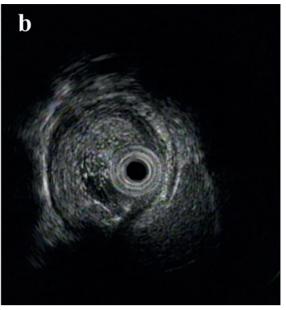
(a) Esophagogastroduodenoscopy revealed a yellowish, elastic, hard submucosal tumor at the anterior wall of the cardia (proximal stomach) approximately 10 mm in diameter with a central depression. (b) Endoscopic ultrasonography located the tumor at the second and third layer. The tumor line was clearly demarcated and the internal echo pattern was heterogeneously hypoechoic.
